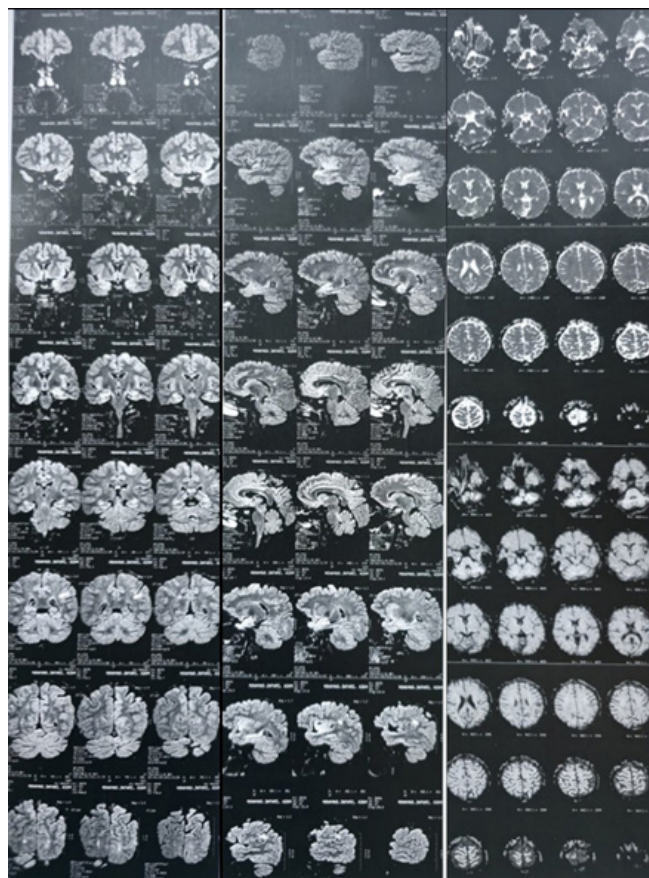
Before exosome; Brain MRI without contrast was done. Technique was axial T1, T2, PD/W and sagittal T2/W and coronal T1W images. Findings are as follows: Evidence of multiple focal abnormal Signal intensity areas in periventricular & pericallosal white matter is seen, which are mostly suggestive of demyelinating plaques of multiple sclerosis.
